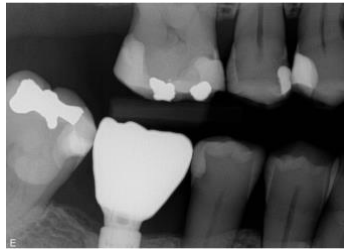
A radiograph taken during a routine follow-up visit 2 years after the study's conclusion revealed nearly complete spontaneous marginal bone regeneration.
